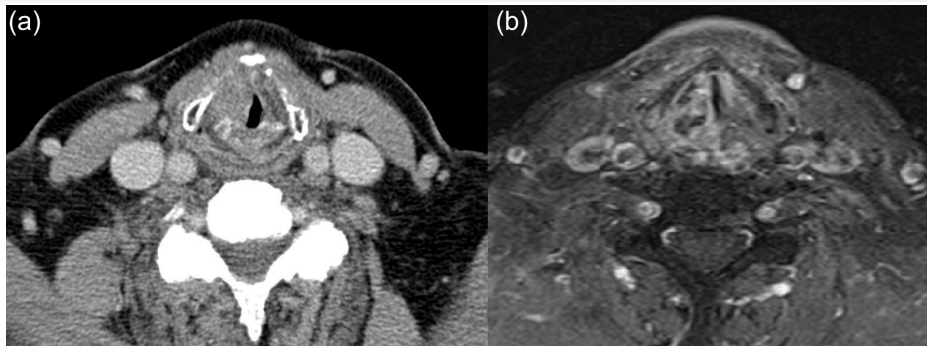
CT and MRI findings of CRN. (A) Mild sclerosis of the arytenoid cartilage with paraglottic space involvement mimicking tumor recurrence on the contrasted CT scan, (B) T1 contrasted MRI of the same patient. Abscess foci in the paraglottic space with contrast enhancement due to inflammation. CT, computed tomography; MRI, magnetic resonance imaging; CRN, chondroradionecrosis.
